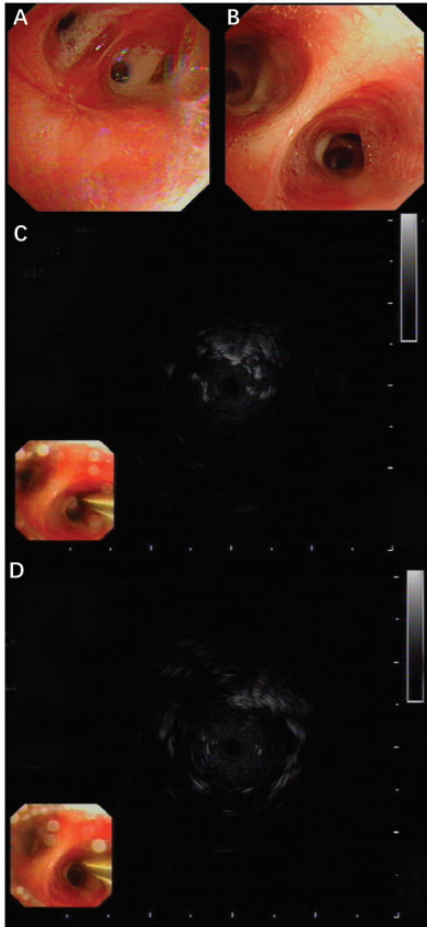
Manifestations on bronchoscopy and EBUS images. (a, b) Bronchoscopy revealed increased secretions from different bronchi. (c, d) The EBUS image revealed heterogeneous internal echoes and an irregular margin of the lesion within the lumen of RB6, with almost no vessels or bronchi within the lesion. EBUS, radial endobronchial ultrasound; RB6, right bronchus 6.
